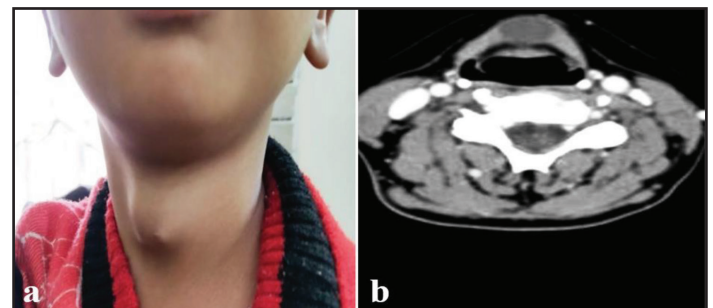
(a) Midline neck cystic swelling; (b) Computed Tomography of the neck showing cystic lesion in the infrahyoid region.
